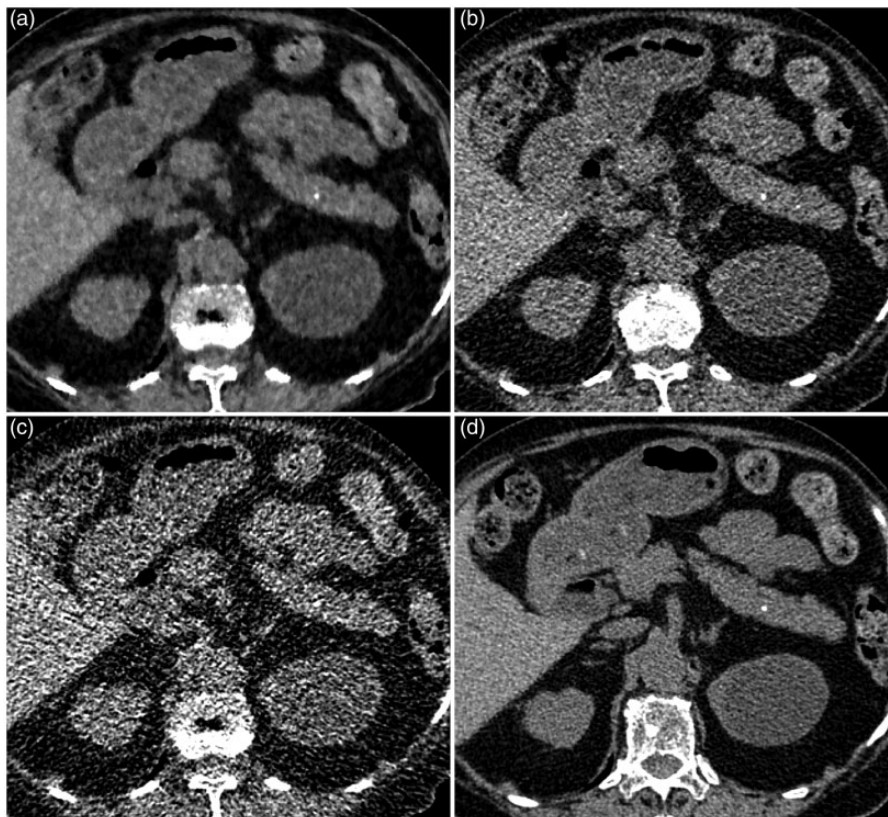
Axial unenhanced CT images of UL-MBIR (a), L-ASIR (b), UL-ASIR (c), and R-FBP (d) of an 82-year-old woman weighing 44 kg. Pancreatic calcification (3 mm diameter) is clearly depicted on UL-MBIR. On UL-MBIR/L-ASIR/UL-ASIR, it was evaluated as 4 (calcification probably present)/2 (calcification probably not present)/3 (calcification presence equivocal) by reader 1 and 4/3/3 by reader 2.
